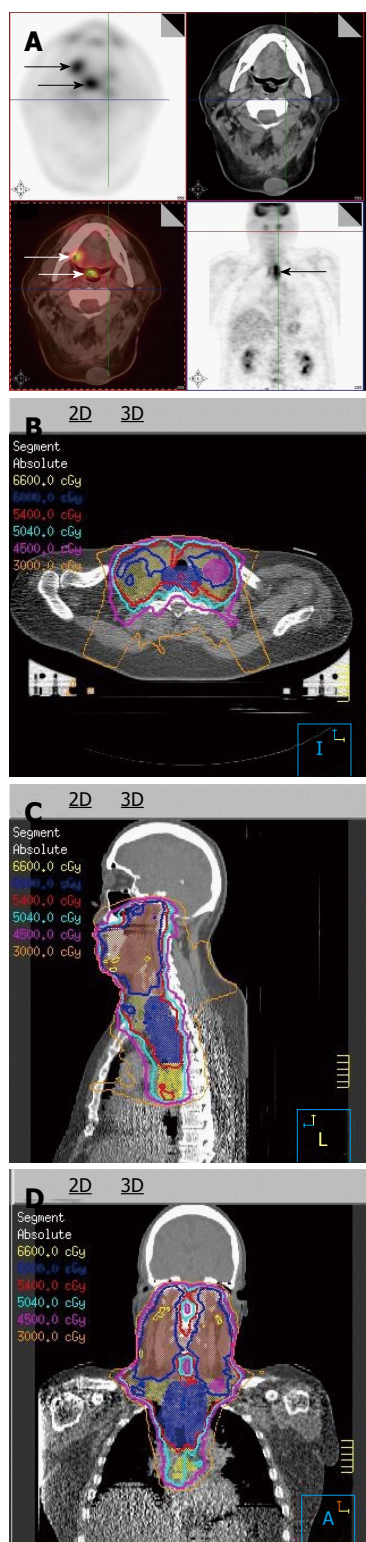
Positron emission tomography/computed tomography discovers multiple primaries in a patient with a right lateral tongue cancer. A: PET/CT images revealed that in addition to an oral tongue tumor, this patient had a primary tumor of the soft palate (inferior white arrow) as well as the cervical esophagus (black arrow); B-D: The IMRT plan for this patient demonstrates all three tumors covered in the high dose CTV. PET/CT: Positron emission tomography/computed tomography; IMRT: Intensity modulated radiation therapy.
